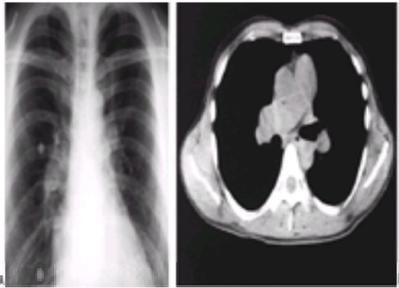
A: On posteroanterior view of the chest in pulmonary hypertension, the central pulmonary arteries are enlarged and the peripheral arteries appear diminutive in size. On a lateral view, a hypertrophied right ventricle may be encroaching on the retrosternal air space. B: The diameters of the main and right pulmonary arteries are easily seen to be greater than the diameter of the adjacent aorta on CT of the mediastinum.
